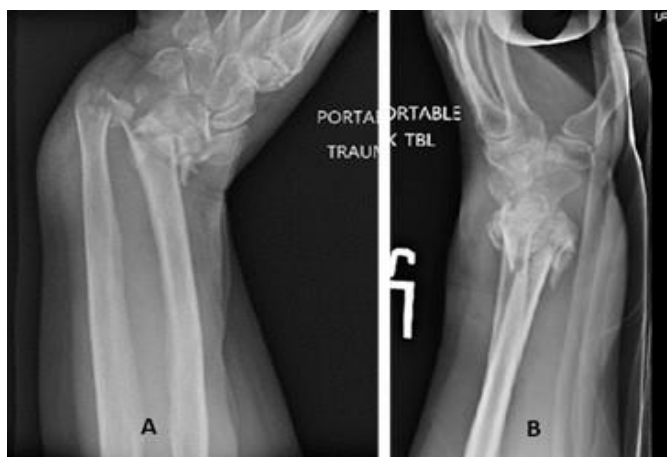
X-rays of initial presentation prior to treatment.
